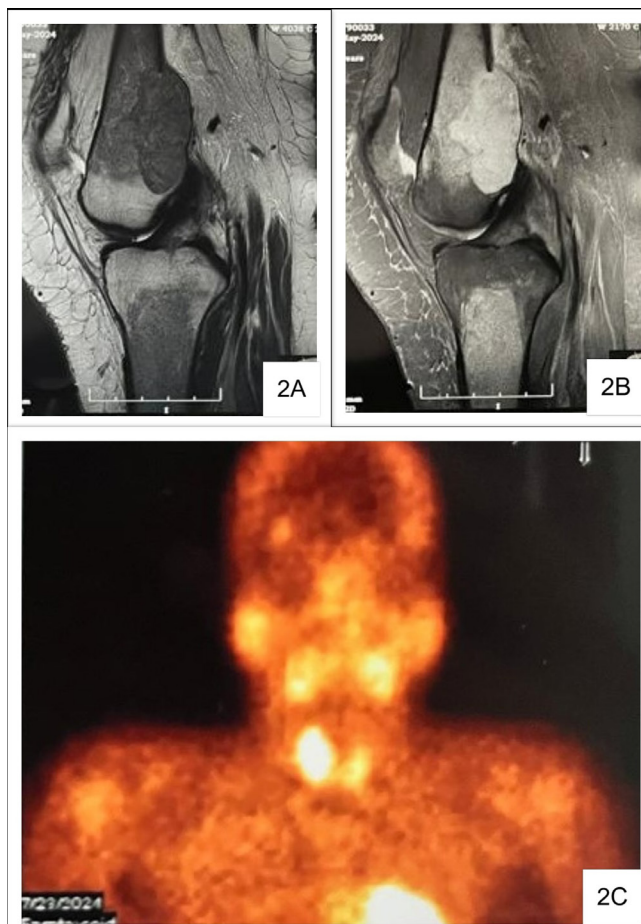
(A), (B). MRI knee image showing T1 hypointense and T2 hyperintense solid cystic lesions respectively. (C). TC99m SESTAMIBI showing right parathyroid lesion.
